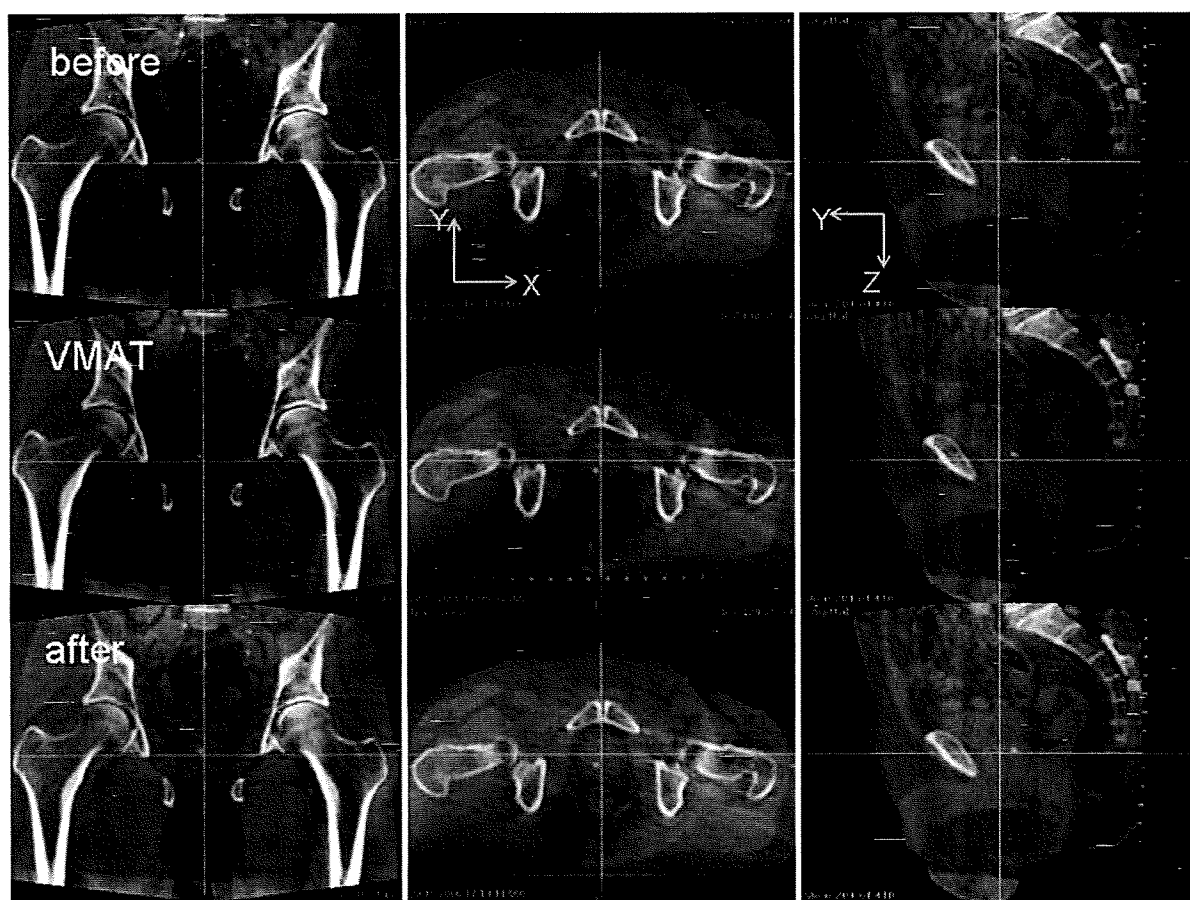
Cone-beam CT images of a prostate cancer patient with calcification inside the prostate organ. Images in the first row were acquired immediately before VMAT treatment after couch adjustment, the second row refers to images during VMAT delivery, and the third row images were taken immediately after the treatment. Crossing lines indicate the isocenter.
